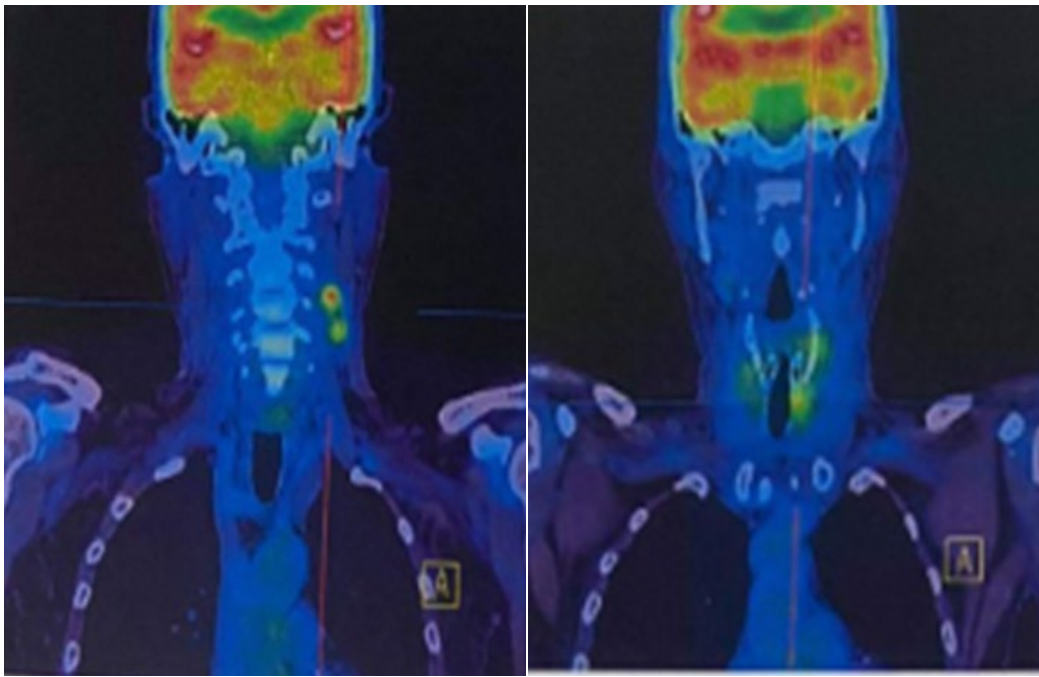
18F-FDG PET/CT scan showing (a) prominent lymph nodes (at least 2 FDG-avid noted) seen along left side of neck (level III) with SUVs up to 8.5; (b) FDG-avid focus in left thyroid bed with SUV max of 6.8.
